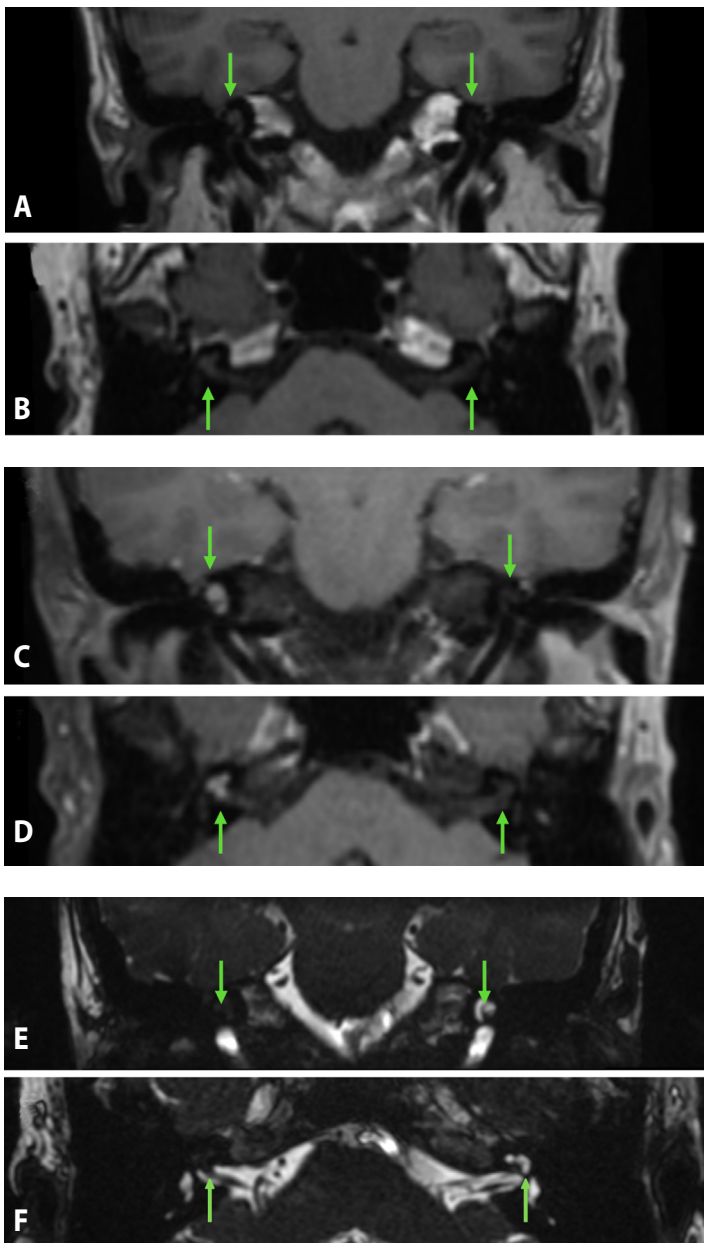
Gadolinium-enhanced MRI of the internal auditory canal, representative cuts with characteristic features of a transmodiolar ILS; arrows point to the cochlea on both sides. A, B: Non-contrast enhanced T1-weighted images (A: coronal, B: axial) showing the lesion is isointense compared to normal brain parenchyma. C, D: Contrast enhanced T1-weighted images (C: coronal, D: axial) demonstrating an appreciable hyperintense lesion in the right cochlea. E, F: T2-weighted images (E: coronal, F: axial) revealing an appreciable signal loss in the cochlea and portion of the distal IAC on the right, characteristic of an ILS.
